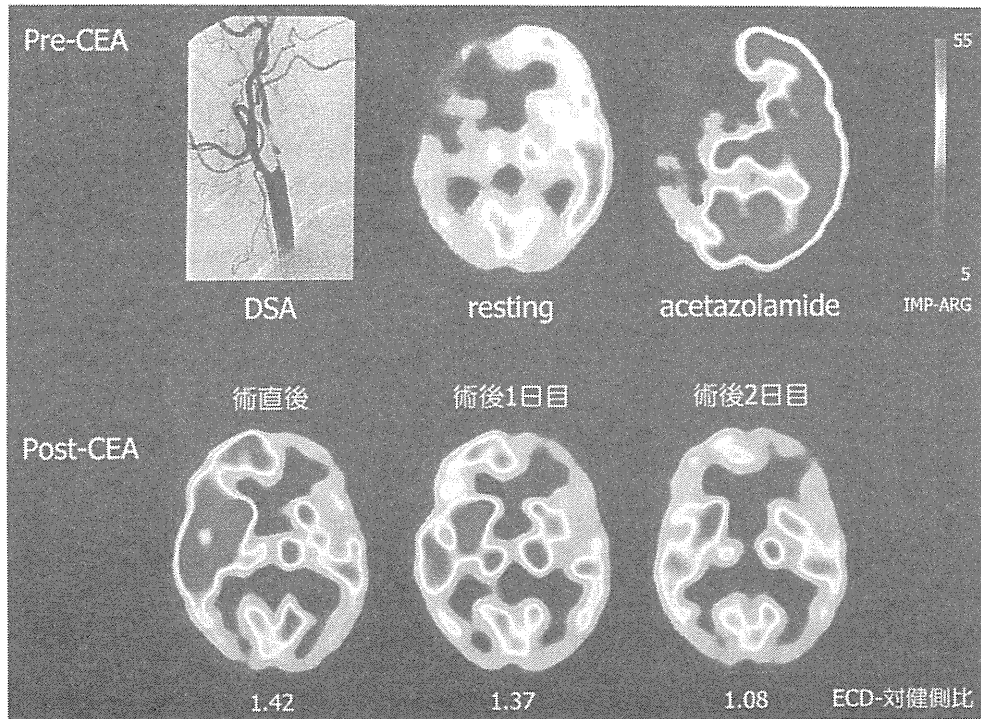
CEA 術後過灌流症候群の SPECT 画像
